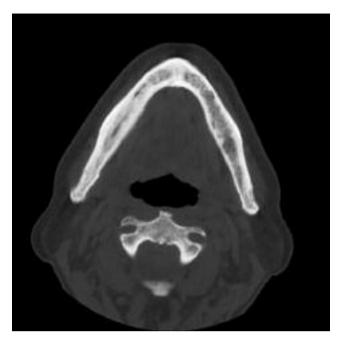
Axial CT scan showing a osteosclerotic process in the right part of the jaw with extensive periosteal reaction.
